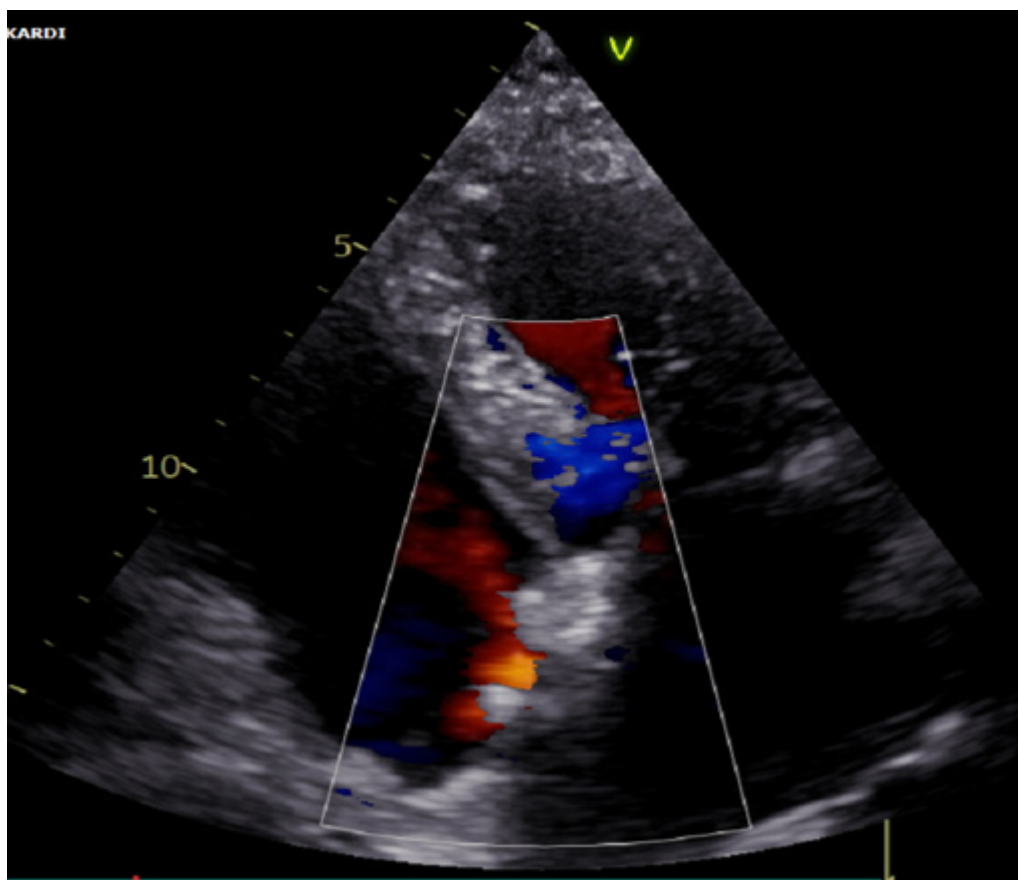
Post-procedural control echocardiography demonstrating an intact interatrial septum
